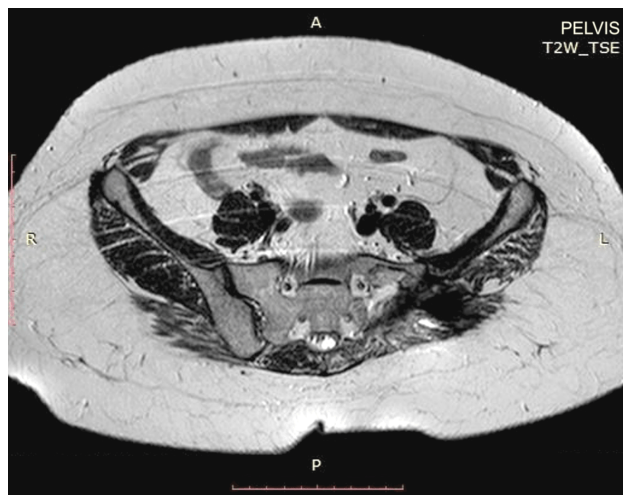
Two-year follow-up contrast-enhanced axial T2W image of MRI. Hypersignal in the postoperative area can be observed on T2W sequence. MRI: Magnetic resonance imaging; T2W: T2-weighted; TSE: Turbo spin echo.
